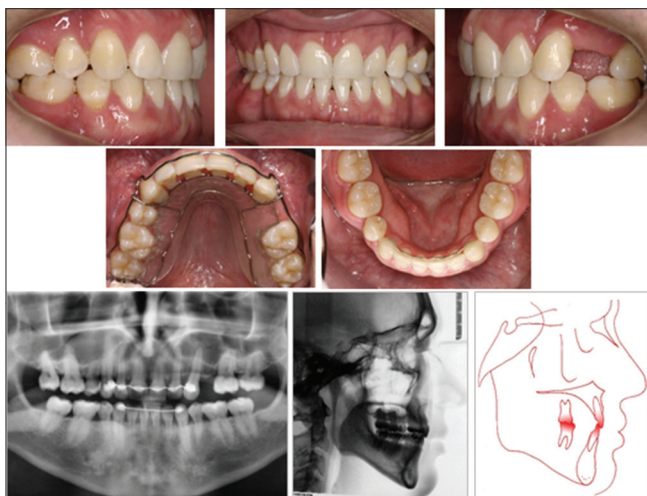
Posttreatment intraoral photographs and panoramic radiograph
